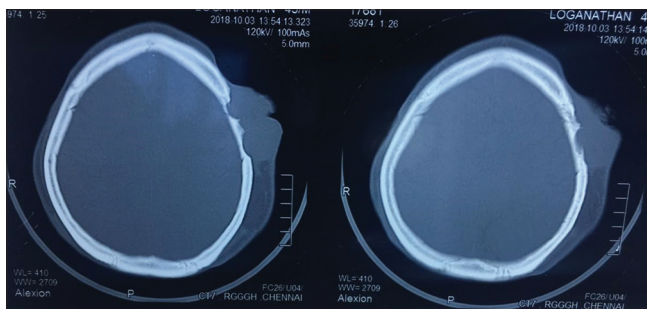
Computed tomography scan – lesion: Recurrent dermatofibrosarcoma protuberance
